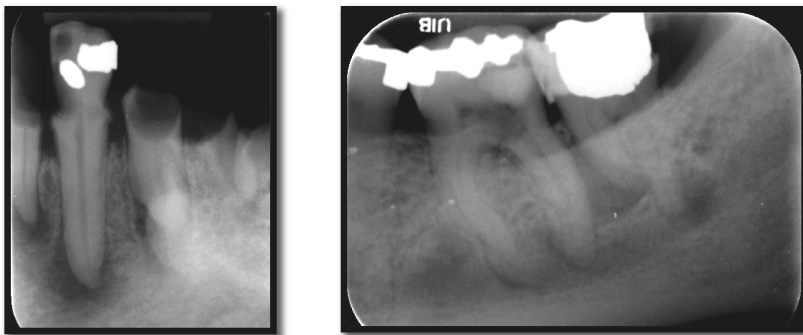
Radiographic exemplifications of teeth with deep, untreated or secondary caries and periapical lesions (unpublished images, Department of Endodontics, University of Bergen).
